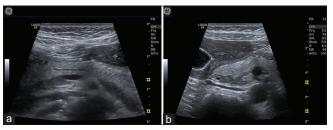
56-year-old female. Hypoechoic ventral part of the pancreatic head – in ultrasound cross-section (a) and longitudinal section (b)
